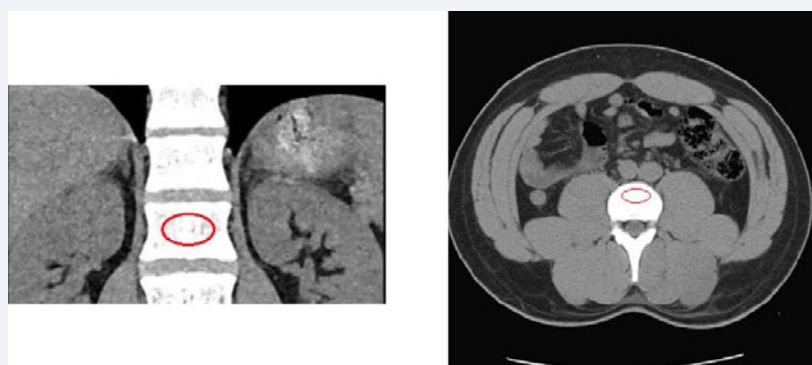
Oval regions selected at the L1 vertebral level of the trabecular bone for BMD estimation on axial and coronal CT-imaging.
